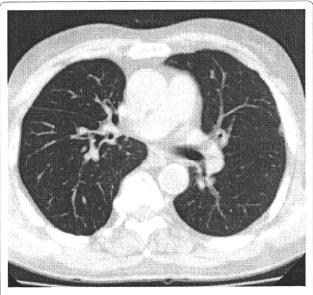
CT images before SBRT (Pt. No. 7).
